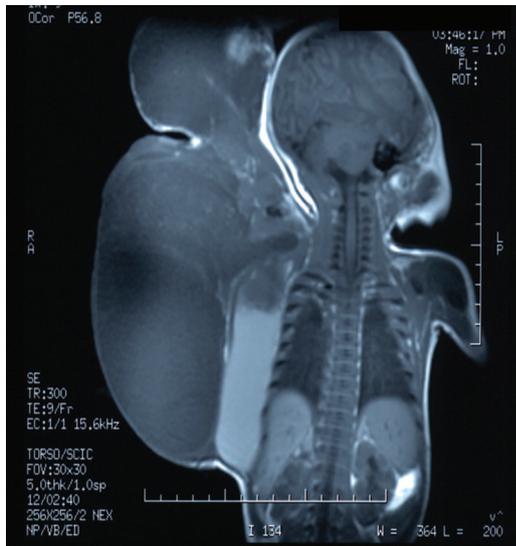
Magnetic resonance imaging scan of the multilocular cystic or cavernous mixed-type lymphangioma infiltrating into the deep area of the right upper extremity and axilla. It was impossible to extirpate the tumor completely.
